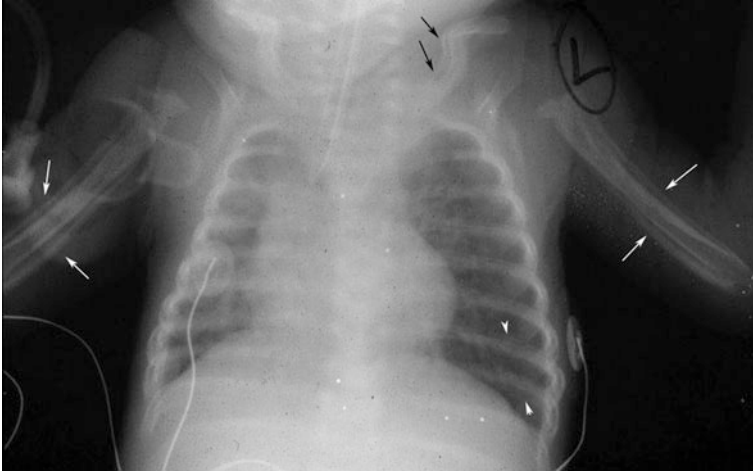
Frontal chest radiograph in an infant with congenital heart disease who received PGE1 therapy showing subperiosteal new bone formation along the shafts of the humeri bilaterally (*white arrows*), ribs (*arrowheads*), and clavicles (better appreciated on the left side shown with *black arrows*)
